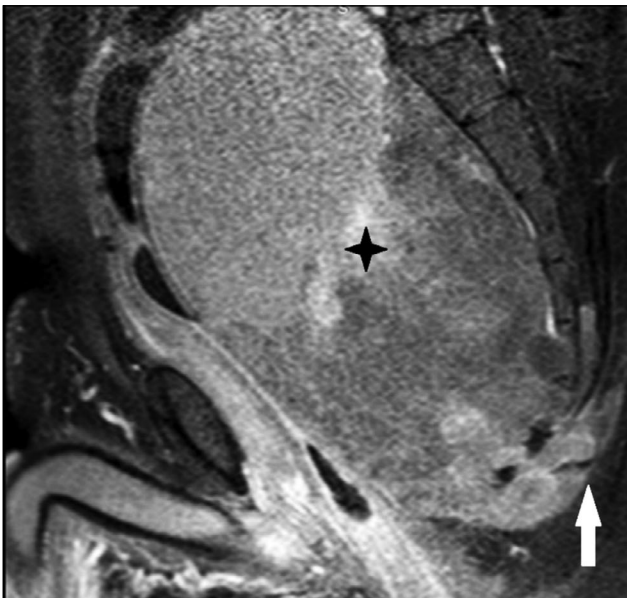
MRI in T1 SPIR mode in the sagittal plane: a significant size, heterogeneously hypointense, with moderately hyperintense areas, the intrapelvic soft tissue component of the tumor (asterisk) is adjacent to the anterior surface of the sacrum, infiltrating muscle tissue in the posteroinferior direction (arrow).
